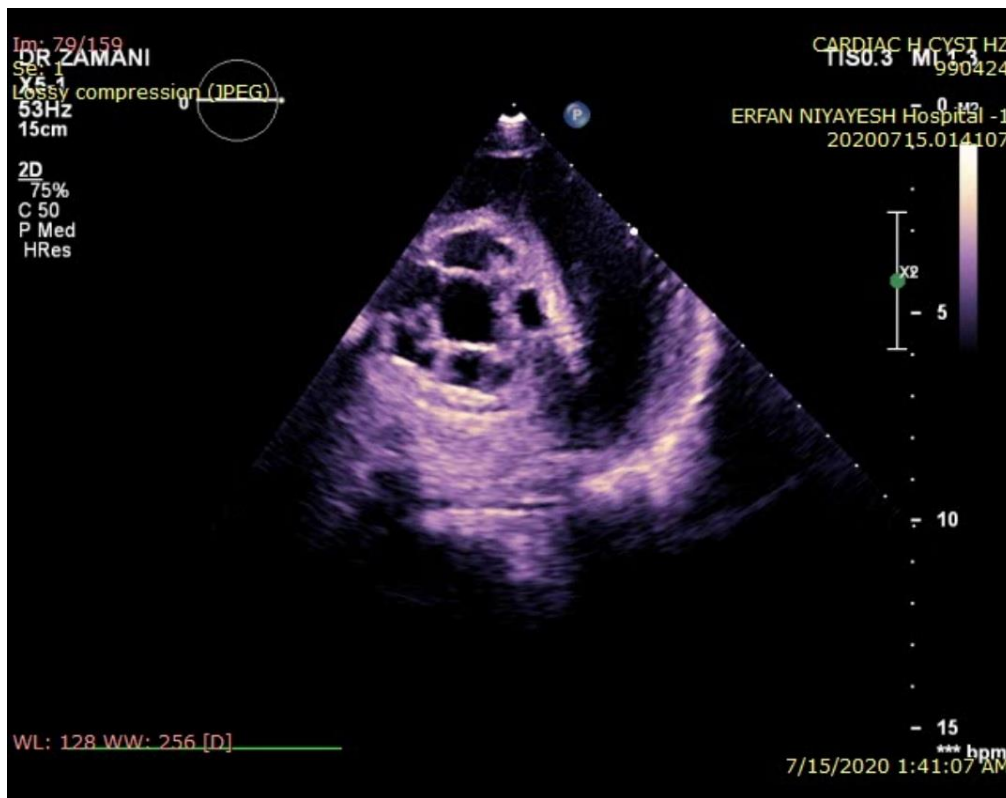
Transthoracic Echocardiographic of interventricular septum hydatid cyst
